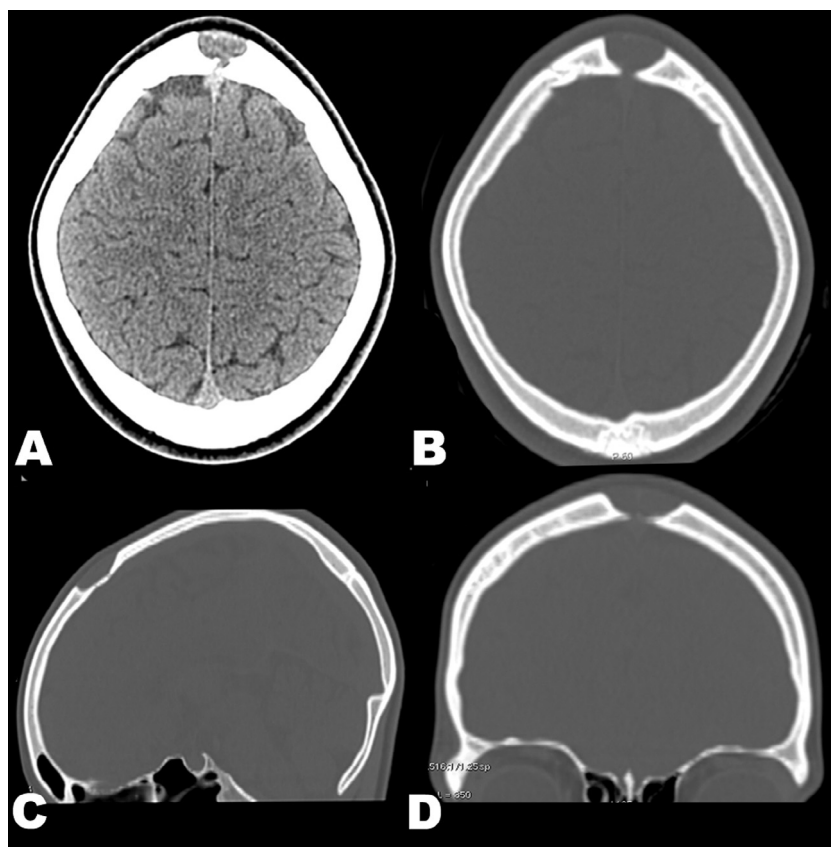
Axial plain CT images brain window (A) and bone window (B) showing soft tissue swelling at the confluence of the sutures; there was smooth scalloping of adjacent bone with just a focal breach of the inner table. Sagittal and Coronal bone window images (C, D) showing the relations of the lesion with underlying sinus.
